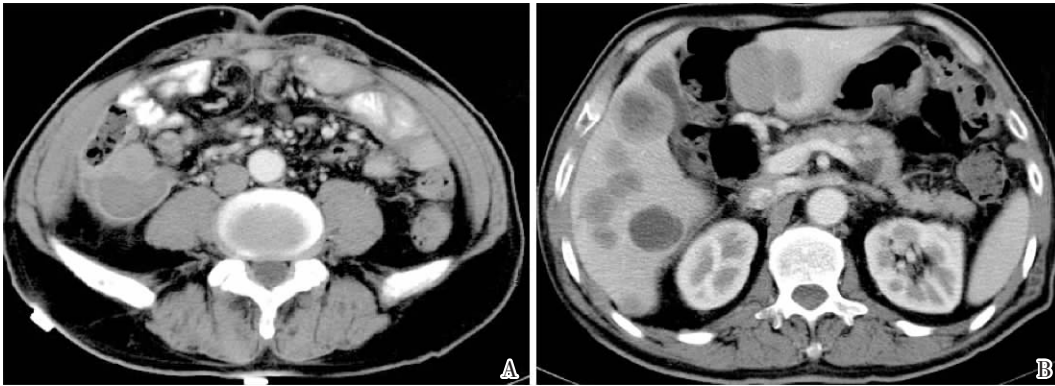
CT features of small mesenteric GIST with multiple liver metastases
